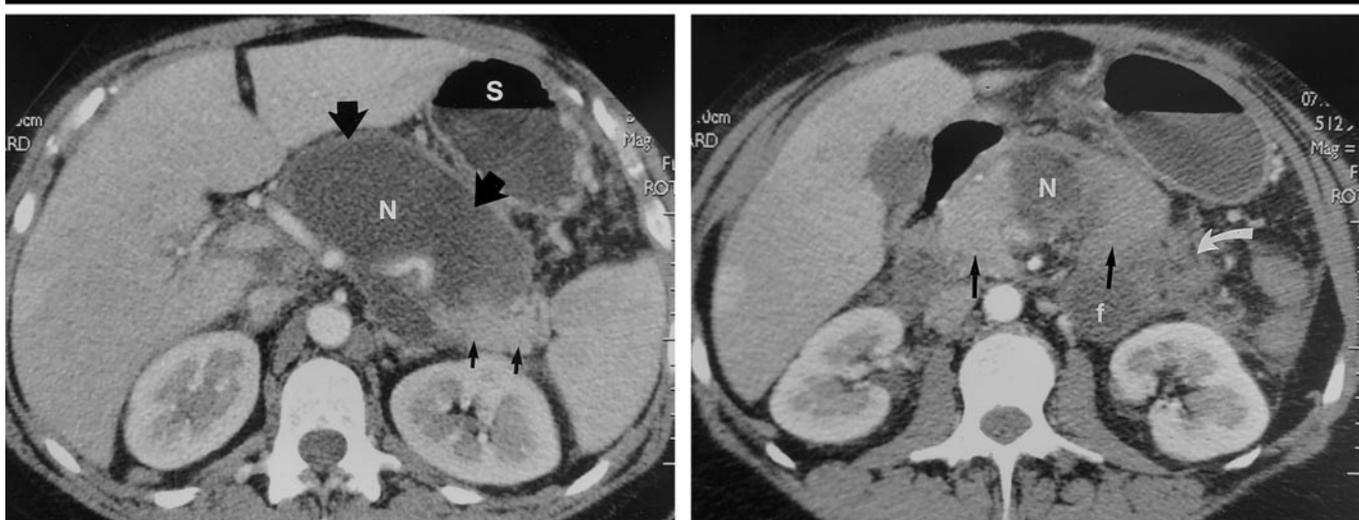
Pancreatic necrosis in a 50-year-old woman after an episode of acute pancreatitis. (a, b) Transverse CT scans obtained with intravenous and oral contrast material reveal an encapsulated fluid collection associated with liquefied necrosis (large straight arrows in a) in the body of the pancreas. The head, part of the body, and the tail of the pancreas are still enhancing (small straight arrows in a, straight arrows in b). Residual fluid collections and areas of soft-tissue attenuation (curved arrow) consistent with fat necrosis are seen adjacent to the pancreas. *f* = fluid, *N* = liquefied gland necrosis, *S* = stomach.
